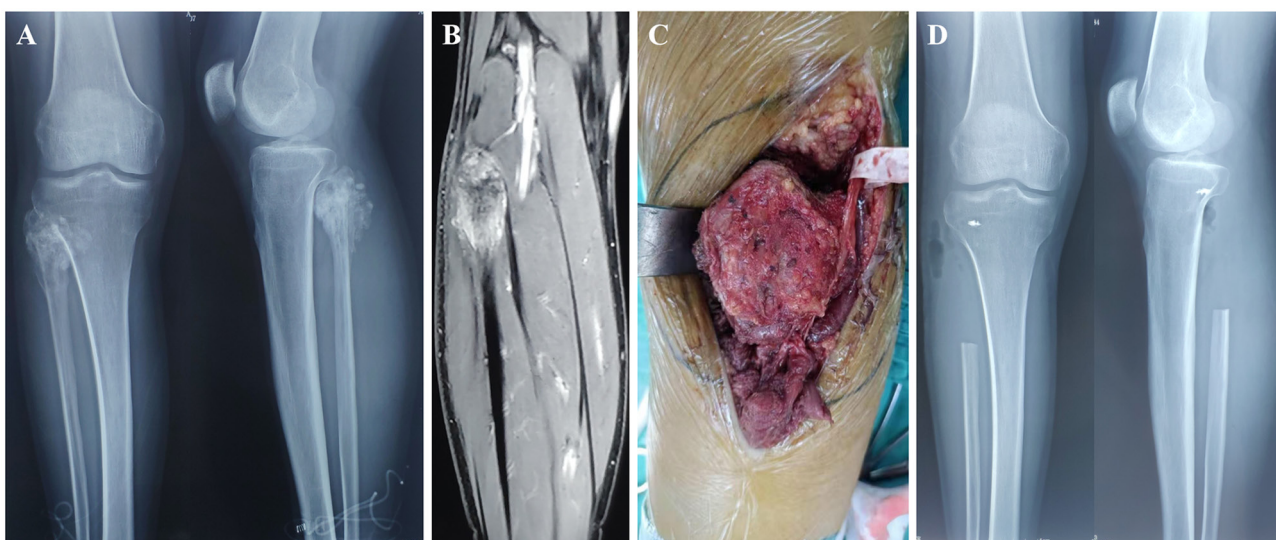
A chondrosarcoma of the proximal left fibula treated with Malawer II resection. (A) Pre-operative X-ray imaging showing the irregular bone destruction with calcification of proximal fibula. (B) MRI showing inhomogeneous high signals in intramedullary lesions and soft tissue masses. (C) The tumour invaded the common peroneal nerve. (D) Postoperative X-ray examination showing good stability of the knee joint.
